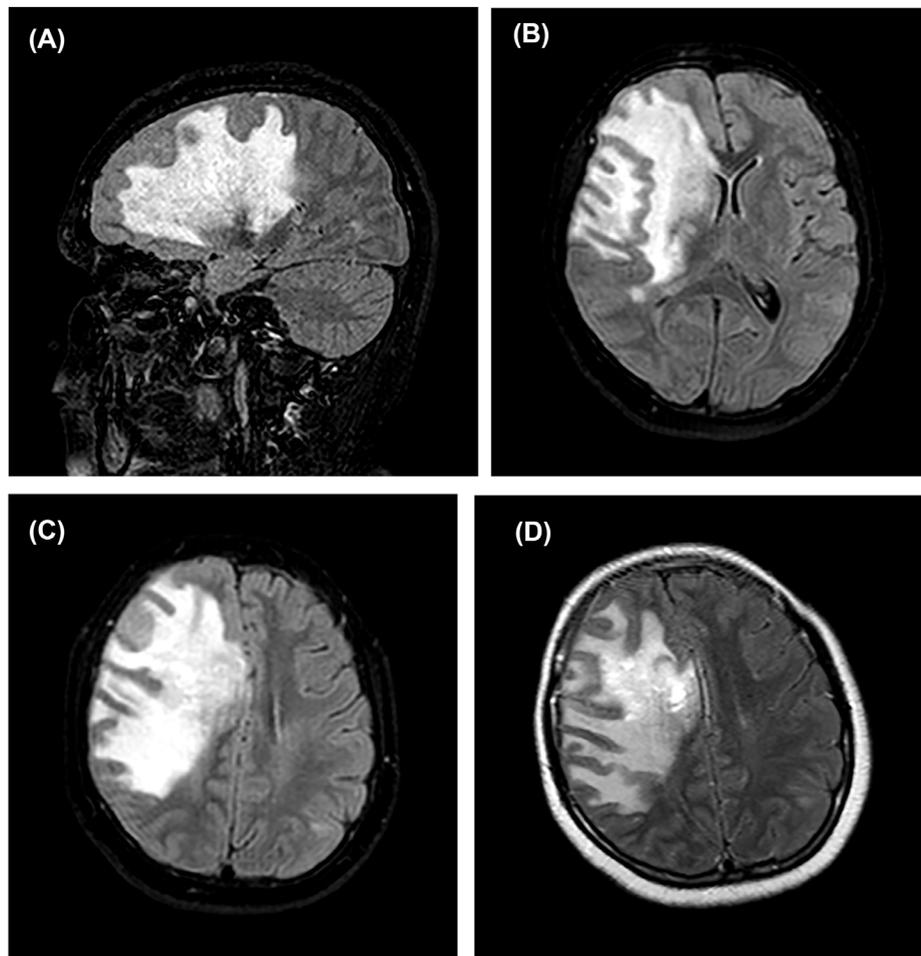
Non-contrast sagittal (A) and axial (B, C) FLAIR MRI showing a diffuse, asymmetric hyperintensity involving supratentorial white matter, thalamus and basal ganglia and producing mass effect. Contrast axial T1-weighted image (D) showing significant gadolinium enhancement.
